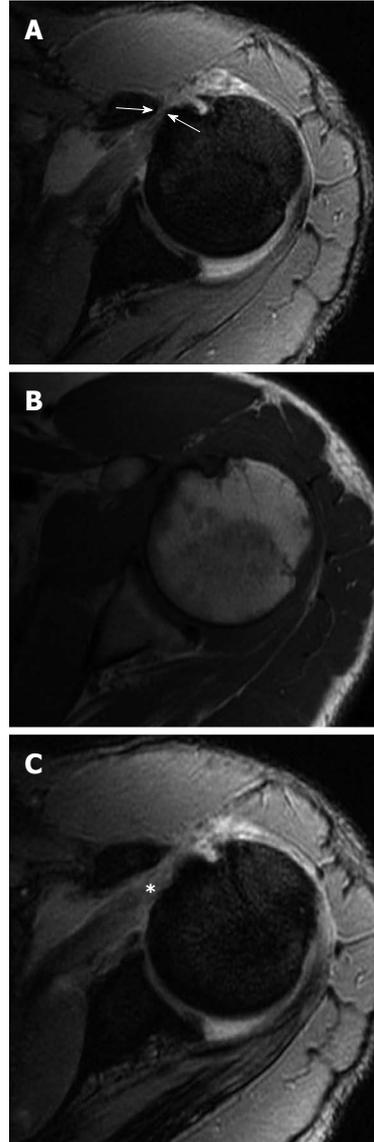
Sub-coracoid impingement. A and C: Axial gradient-recalled echo images; B: Axial T1-weighted image showing narrowed coraco-humeral distance (arrows in A) with tapered coracoid process, thickening and abnormal high signal of the subscapularis tendon (asterisk in C).
